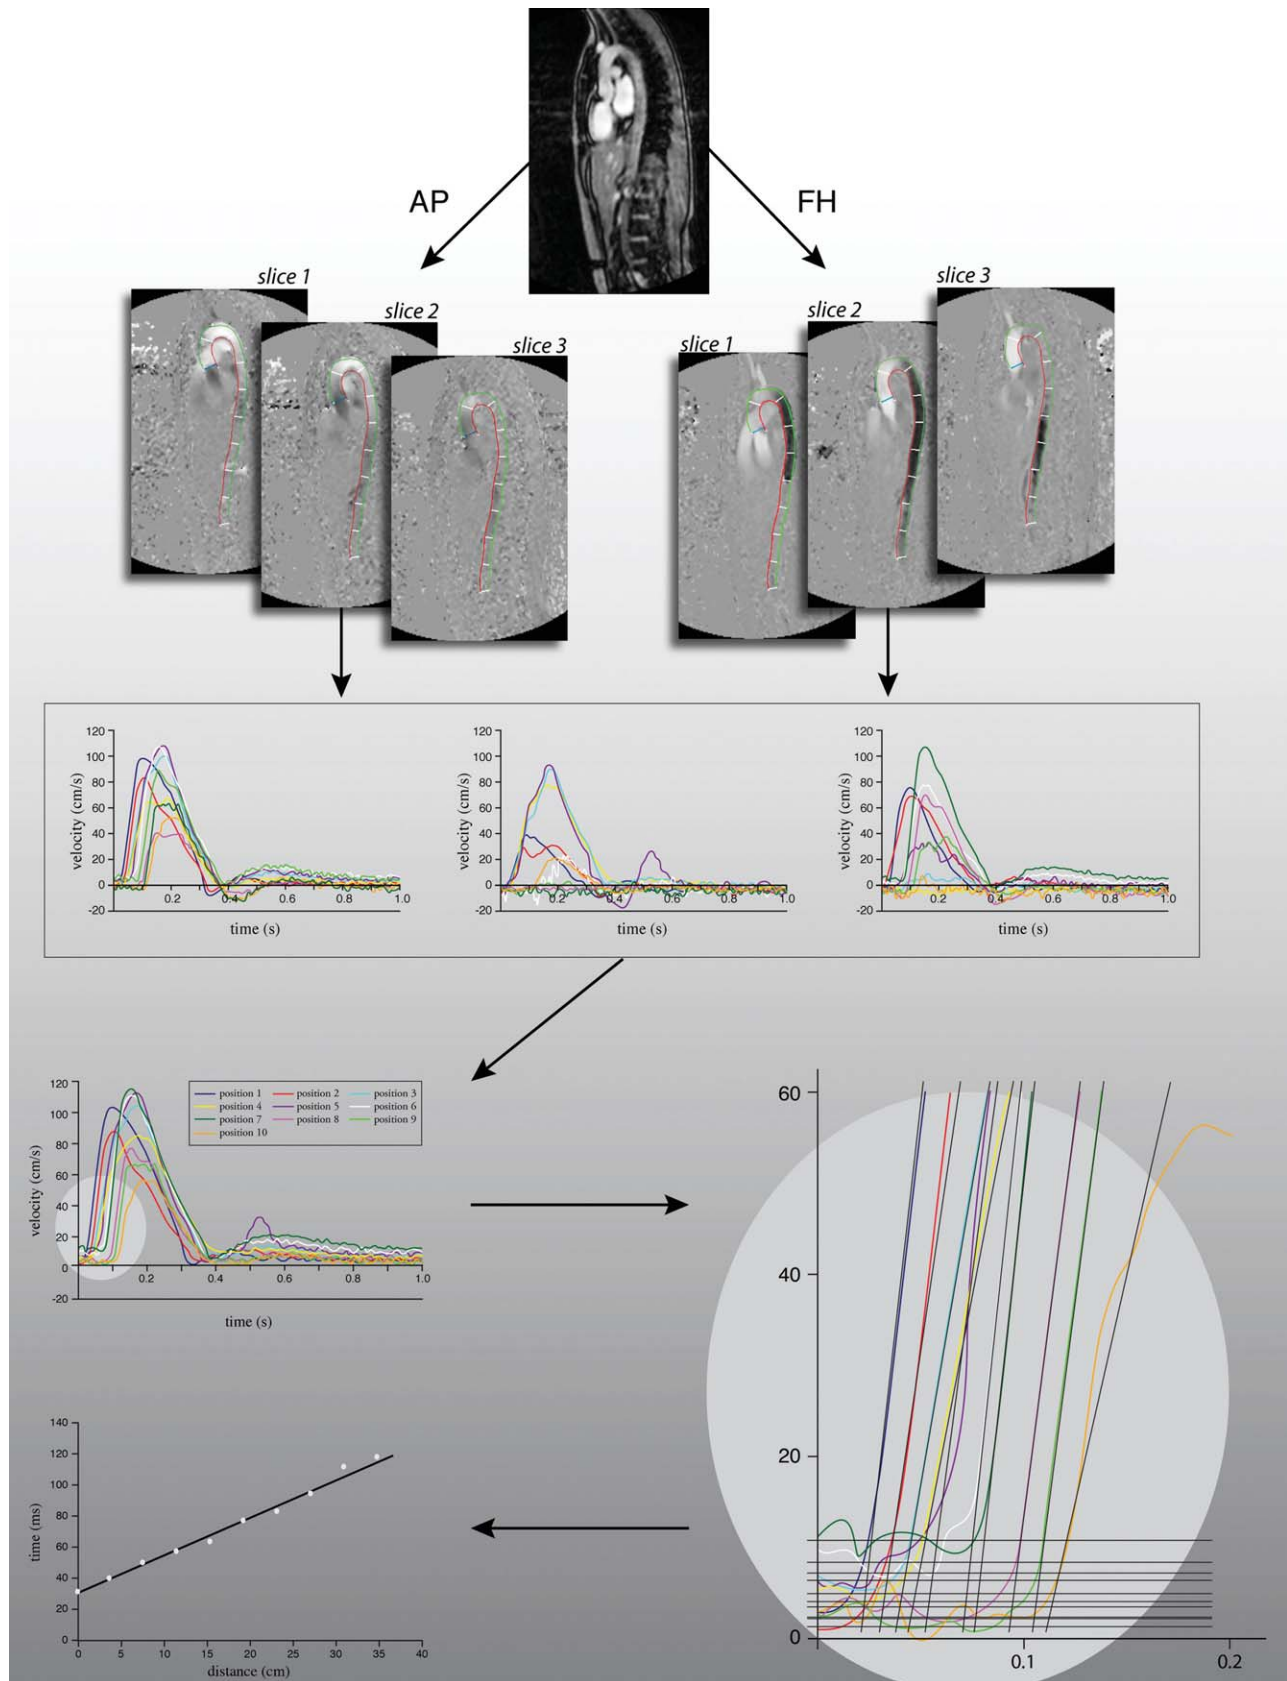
PWV_{i,p} assessment by multislice two-directional in-plane velocity-encoded MRI. A double-oblique stack of three consecutive slices covering the full aorta is acquired with anterior-posterior and feet-head velocity-encoding (panels second row). Flow velocity waveforms are determined from the maximal velocity detected over the lumen per phase at 200 sample points equidistantly distributed along the centerline of the aorta. For each slice, this results in 200 flow velocity-time graphs (panels third row). For each sample point and each phase, the maximal velocity value over the three slices is determined (ie, maximal velocity projection), resulting in the maximal flow velocity wave form of blood flowing along the aorta (panel fourth row left). The arrival time of each of the 200 wave forms at their corresponding positions along the aortic centerline is automatically determined by the transection of the mean diastolic flow velocity and the upslope of the systolic wave front (panel fifth row right). The arrival times are plotted against the position along the centerline and PWV_{i,p} between two measurement sites is determined by the inverse of the slope, determined by linear regression of the arrival time-position relation (panel fifth row left). In the velocity graphs, waveforms at only 10 sample locations are presented.
